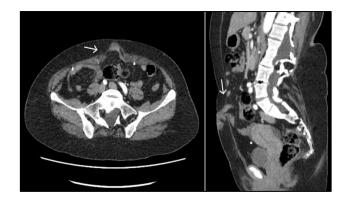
CT scan. On the left, an axial section of the preoperative CT scan showing an abdominal wall defect (arrow) at the umbilicus, with protrusion of an ileum loop. On the right, a sagittal reconstruction of the same CT scan.
